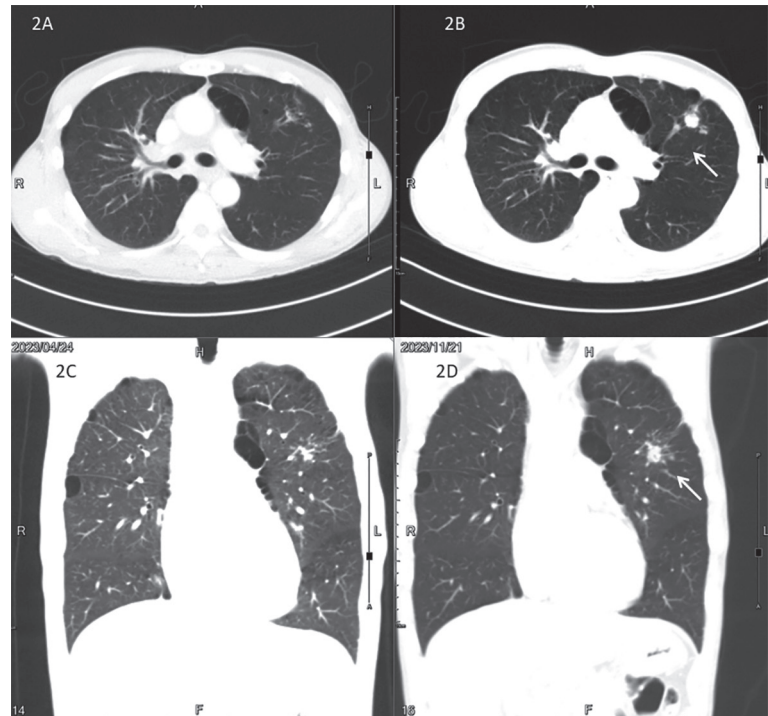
Changes in granulomatous lesion imaging before and after combination ICI therapy. Initial computed tomography at the time of diagnosis of lung cancer reveals a small fibrocalcified granulomatous lesion (arrow) in the anterior segment of the left upper lobe (1A: axial view; 1C: coronal view). Progressive changes in the granulomatous lesions (arrowhead) are observed after combination ICI therapy (2B: axial view; 2D: coronal view).
